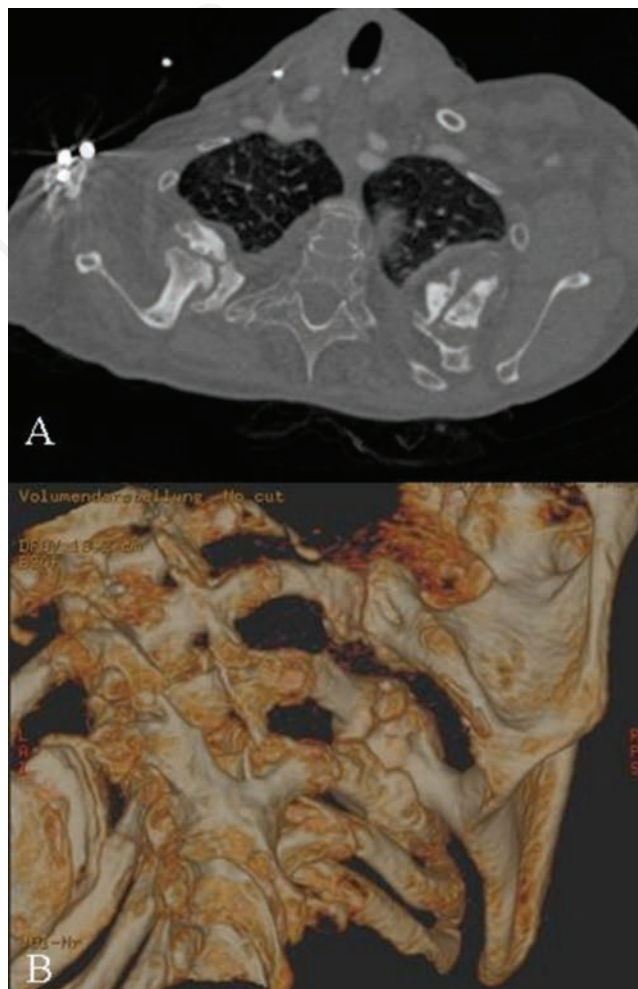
Axial (A) and 3D reconstructed (B) computed tomography scan showing an osteochondroma in the right scapulothoracic space.
